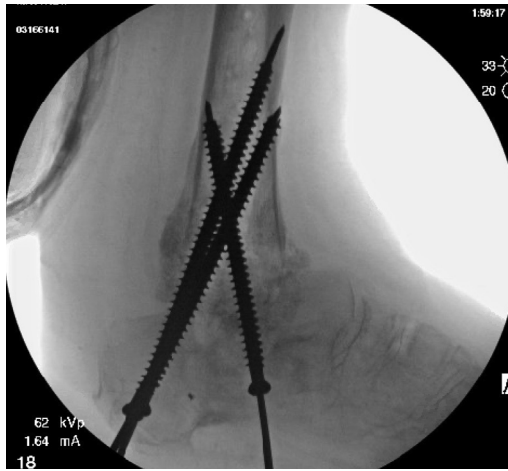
An intraoperative lateral radiograph demonstrating 3 large cancellous screws inserted from the inferior calcaneal cortex to tibial cortex as positional screws. Note that there is no compression over the bone graft.
